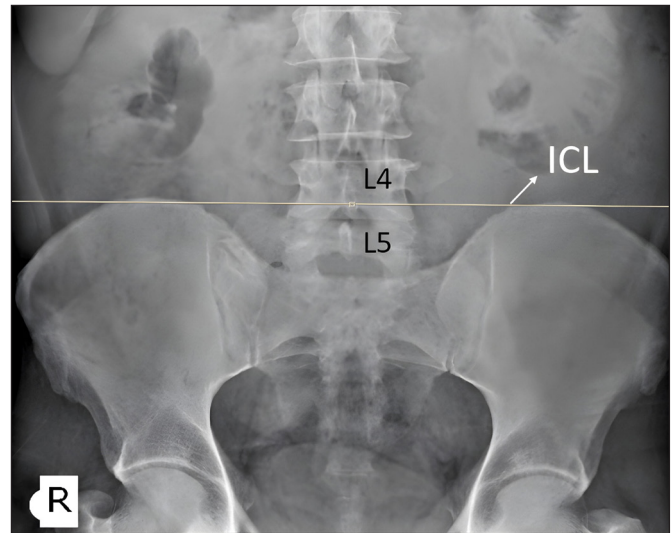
On the anteroposterior plain radiograph, the ICL passes through the L4 corpus (deeply seated L5 vertebra).
